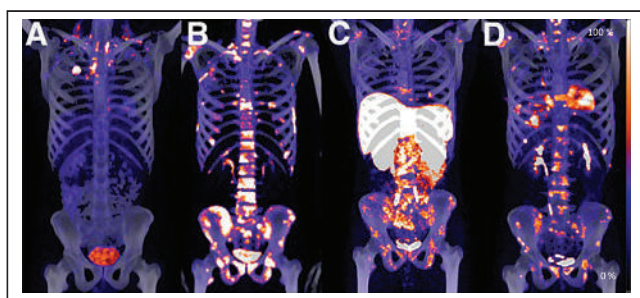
(A) Initial staging ^{18}F -FDG PET/CT scan. (B) Seven months later, ^{18}F -fluoride PET/CT scan shows diffuse bony metastasis. (C) Additional ^{68}Ga -DOTATATE PET/CT scan 2 wk later shows bony lesions less prominently than on ^{18}F -fluoride scan, somewhat similar to follow-up ^{18}F -FDG PET/CT scan. (D) Follow-up ^{18}F -FDG PET/CT scan 1 wk later shows bony lesions and pleural and liver disease.
